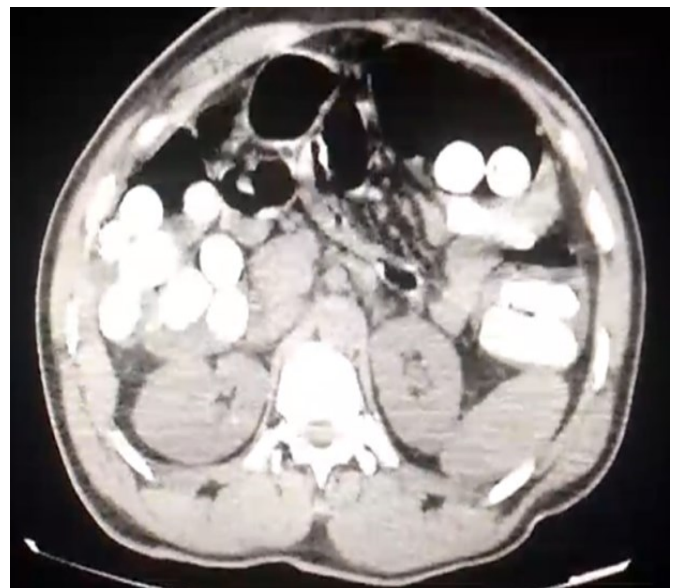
Axial CT showing multiple oval shaped formations in the digestive tract.
